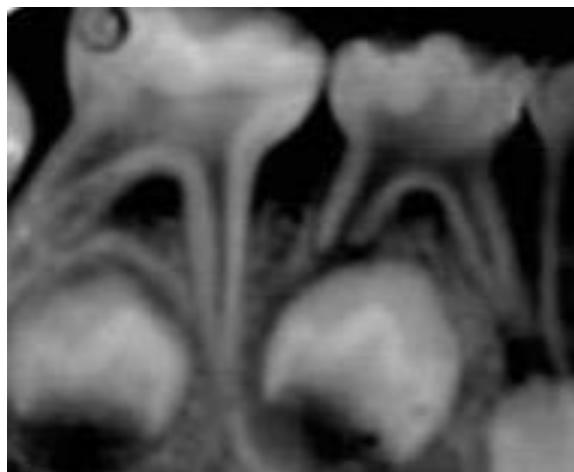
Arrow shows periapical abscesses with no clear evidence of decay or trauma (Hernández and Laguna, 2013, pp.101-108)
